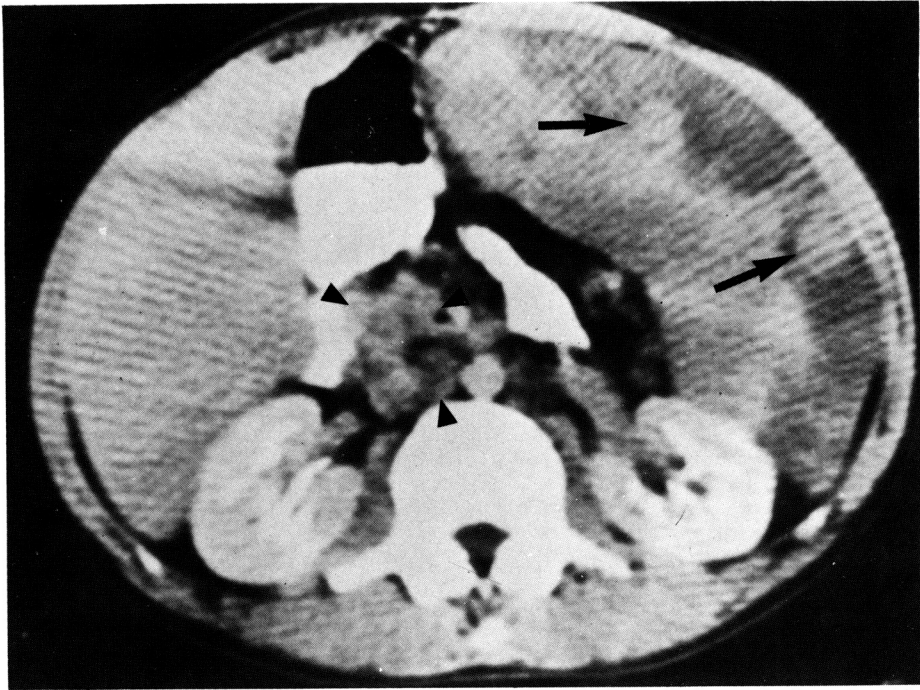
B. CT scan at the level of renal hila reveals intraabdominal lymphadenopathy (arrowheads) and two foci of high density (arrows) in the band-like splenic infarction.
